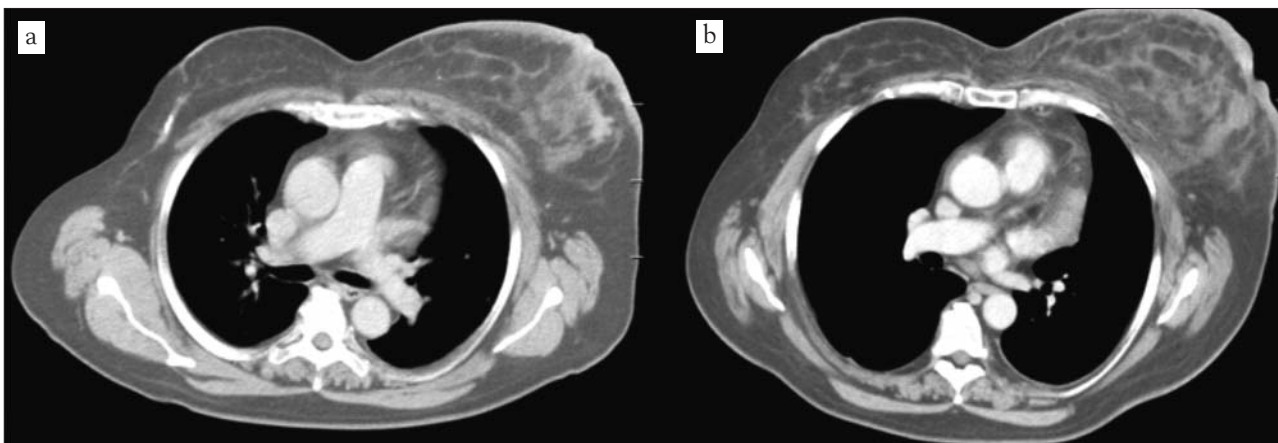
Thoracic transverse CT scans featuring the left breast in (a) June 2014, then in (b) July 2015
